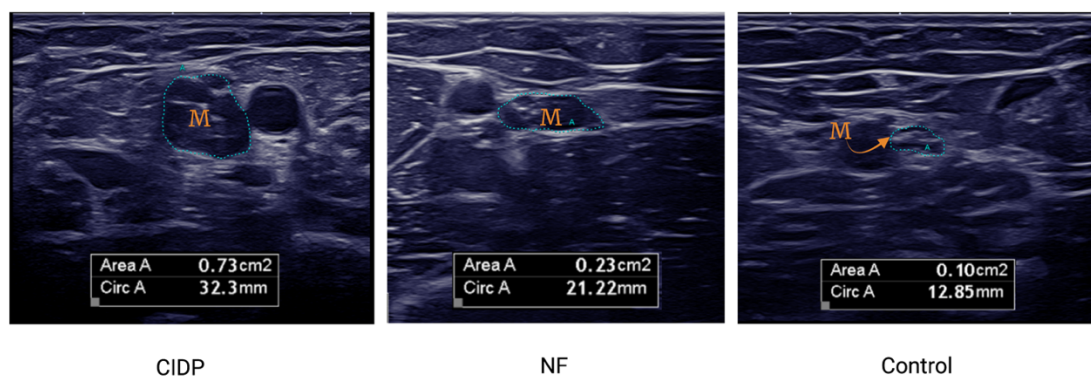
Cross-sectional B-mode ultrasound of median nerve in upper arm. (Own representation) Here the cross-sectional areas of the median nerve in the upper arm are compared between CIDP, Neurofibromatosis (NF) and a Control. The blue dotted line shows the outline of the median nerve, and the orange 'M' is to show where the median nerve is. Each picture has a box in the middle bottom with 'Area A' which means cross sectional area and 'Circ A' which means circumference. Notice that the CIDP (0.73cm²) and the NF (0.23cm²) nerve have a higher cross-sectional area than that of the Control (0.10cm²).
